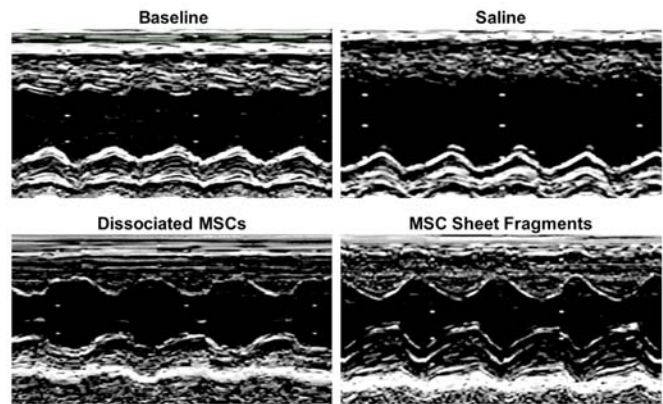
Representative traces of LV short-axis M-mode echocardiograms obtained at baseline (at 4 weeks after MI induction) and at 4 weeks after treatment.
